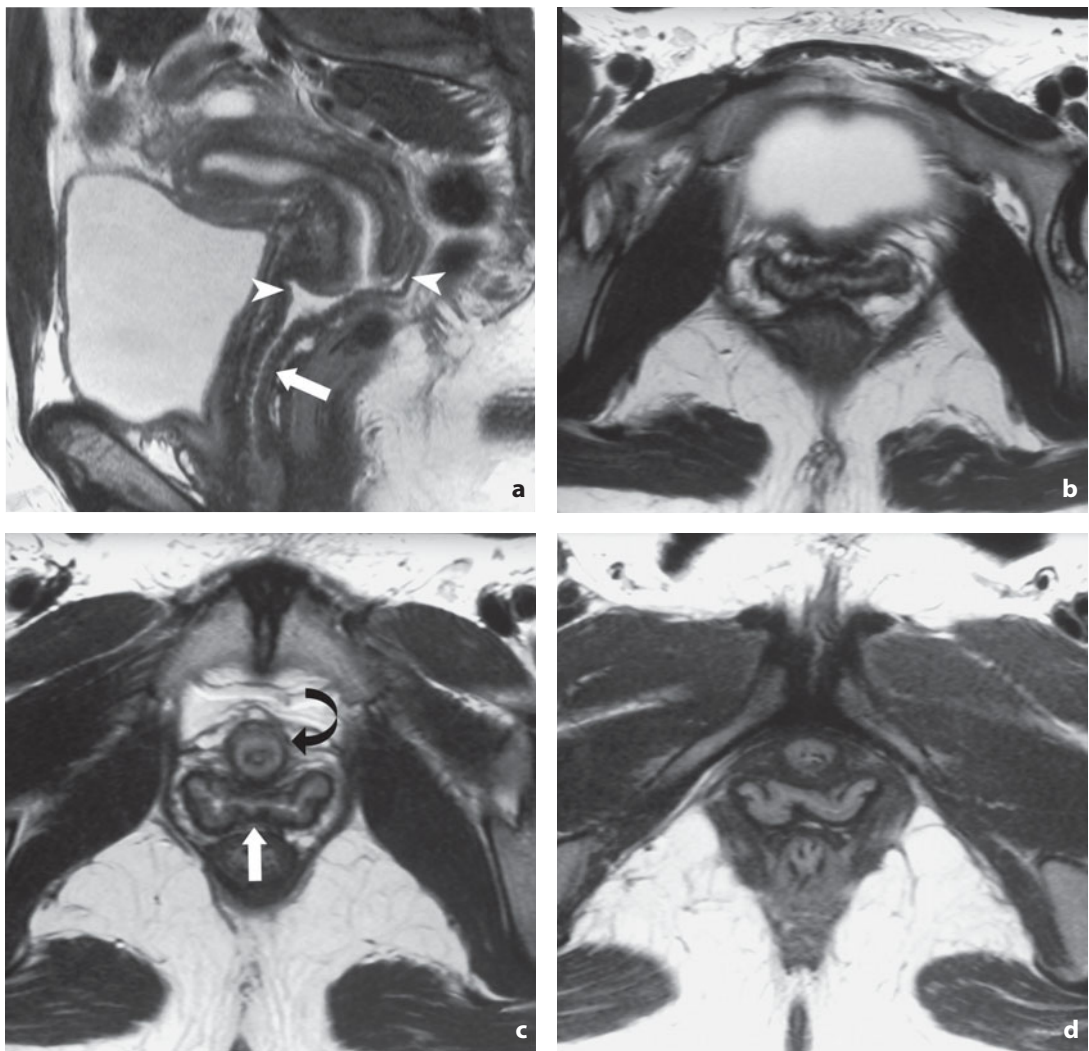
Magnetic resonance. Normal anatomy of the vagina. T2-weighted sagittal (a) and axial images at the superior third (b), middle third (c) and inferior third (d). The *arrowheads* indicate the fornices, the *arrow* the vagina and the *curved arrow* the urethra
